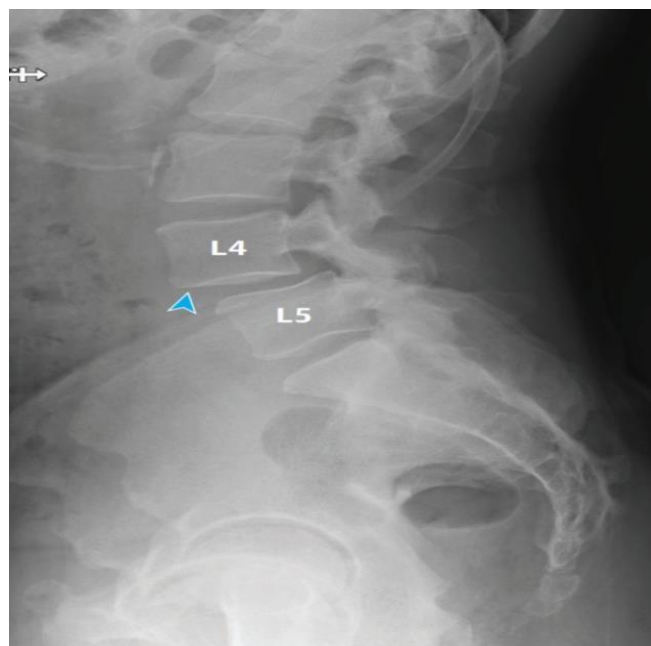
Plain Radiograph Showing L4-5 Spondylolisthesis in a 71-Year-Old Man.
